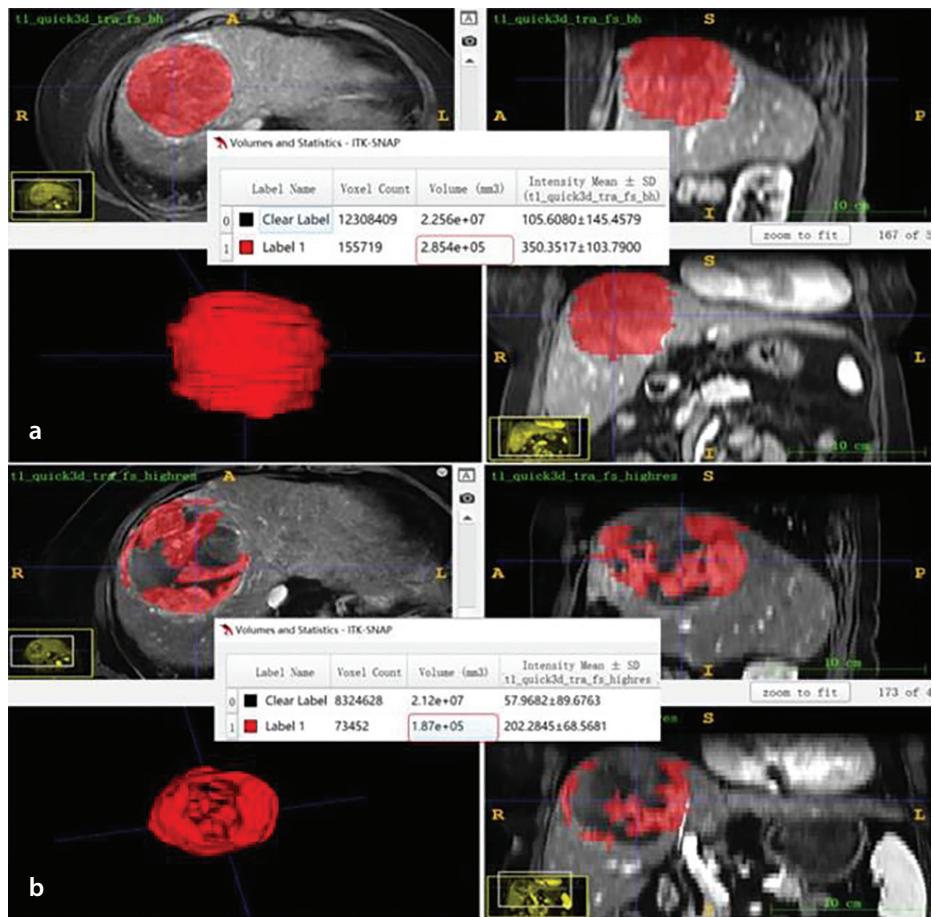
Images of a 76-year-old female patient with hepatocellular carcinoma. Arterial phase contrast-enhanced T1-weighted imaging before transarterial chemoembolization (TACE) revealed a tumor with a volume of 285,400 mm³ in the right liver lobe (a). Contrast-enhanced T1-weighted imaging in the arterial phase revealed heterogeneous enhancement 30 days after TACE. The volume of tumor enhancement (viable tissue) was 187,000 mm³ (b).
